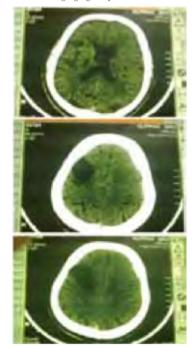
Repeat CT- brain taken 8 months later reveals old infarct with gliotic changes in right high parietal and occipital region
